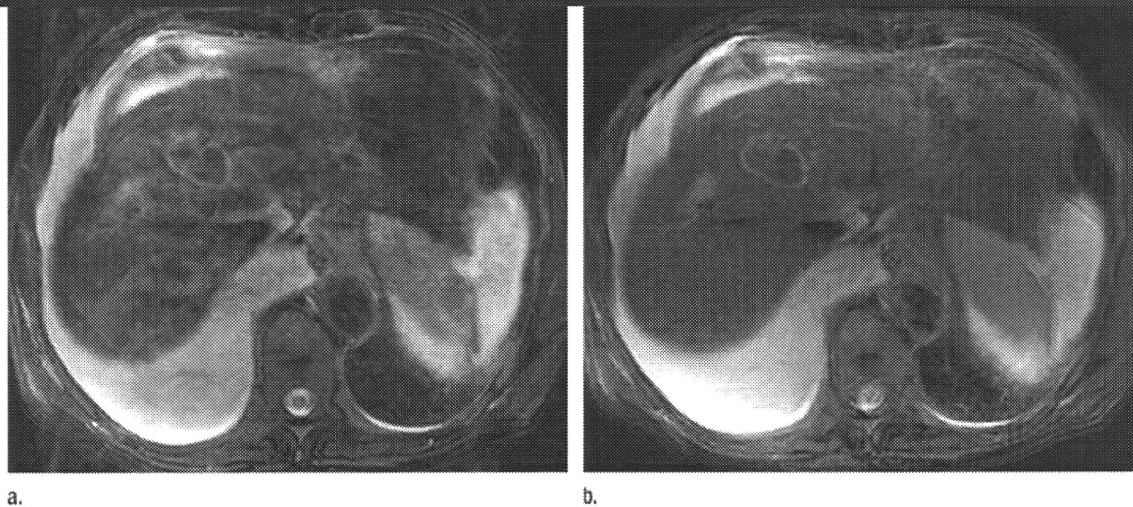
Follow-up fat-saturated T2-weighted TSE axial MR images obtained after SPIO administration with respiratory triggering in a 55-year-old woman with hepatocellular carcinoma, liver cirrhosis, and ascites. (a) Image acquired with the PACE method alone shows that it is difficult to evaluate hepatic lesions in detail because of poor image quality. (b) In addition to the posttherapeutic (radiofrequency ablation) hepatic lesion for hepatocellular carcinoma in segments IV and VIII, the PROPELLER MR image clearly shows a solid hepatic lesion suspected to be the recurrent hepatocellular carcinoma in segment VIII.
